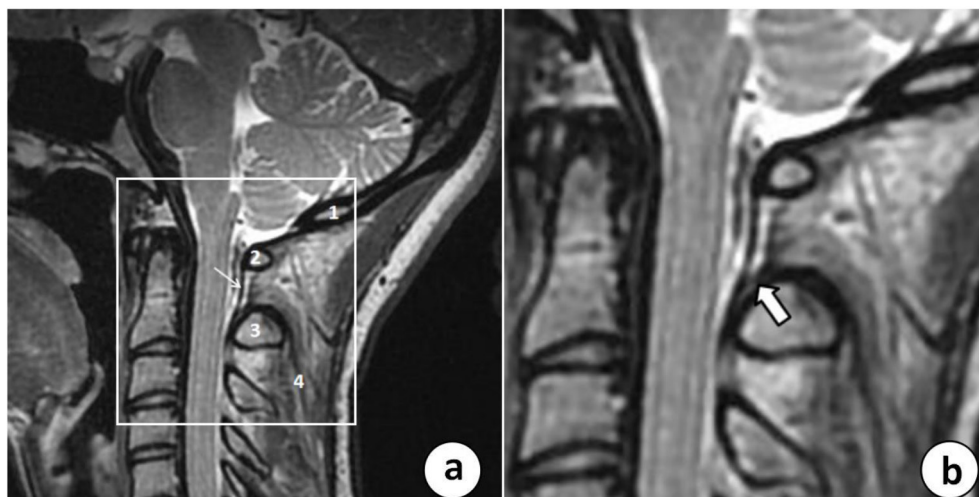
(a,b). Midsagittal T_2 -weighted MR images show hypo-intense myodural bridge (b: blank thick arrow) from nuchal ligament attaching to the dura mater (a: white thin arrow) in the posterior atlanto-axial interspace. (1. occipital bone, 2. atlas, 3. axis, 4. nuchal ligament).
